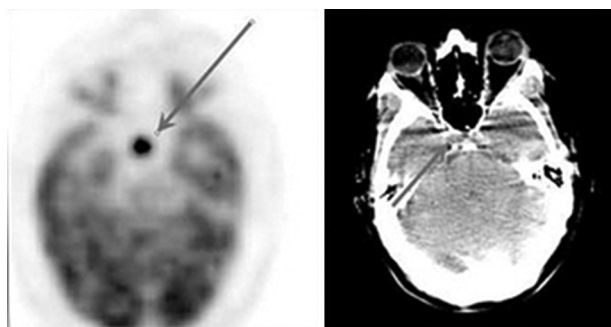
Whole-body and brain ^{18}F -FDG PET/CT images of a 49-year-old man with biopsy-proven small lymphocytic lymphoma demonstrating incidental pituitary uptake. The initial staging PET/CT revealed widespread hypermetabolic lymphadenopathy and bone marrow involvement, along with an intense focus of FDG uptake in the sellar region (SUV_{max} 16.6; white arrow), raising suspicion for pituitary involvement or a benign adenoma. Following chemotherapy, a repeat PET/CT showed complete metabolic response of all lymphoma lesions, while persistent intense pituitary hypermetabolism (SUV_{max} 18.6; white arrow) remained, consistent with a benign pituitary adenoma. Subsequent gadolinium-enhanced MRI confirmed a 7.5×5.5 mm well-defined pituitary lesion with lack of enhancement relative to the surrounding gland, characteristic of a non-functioning pituitary adenoma. This figure is adapted from Karapolat *et al.*,²⁴ available under a Creative Commons Attribution (CC BY 3.0) license.
